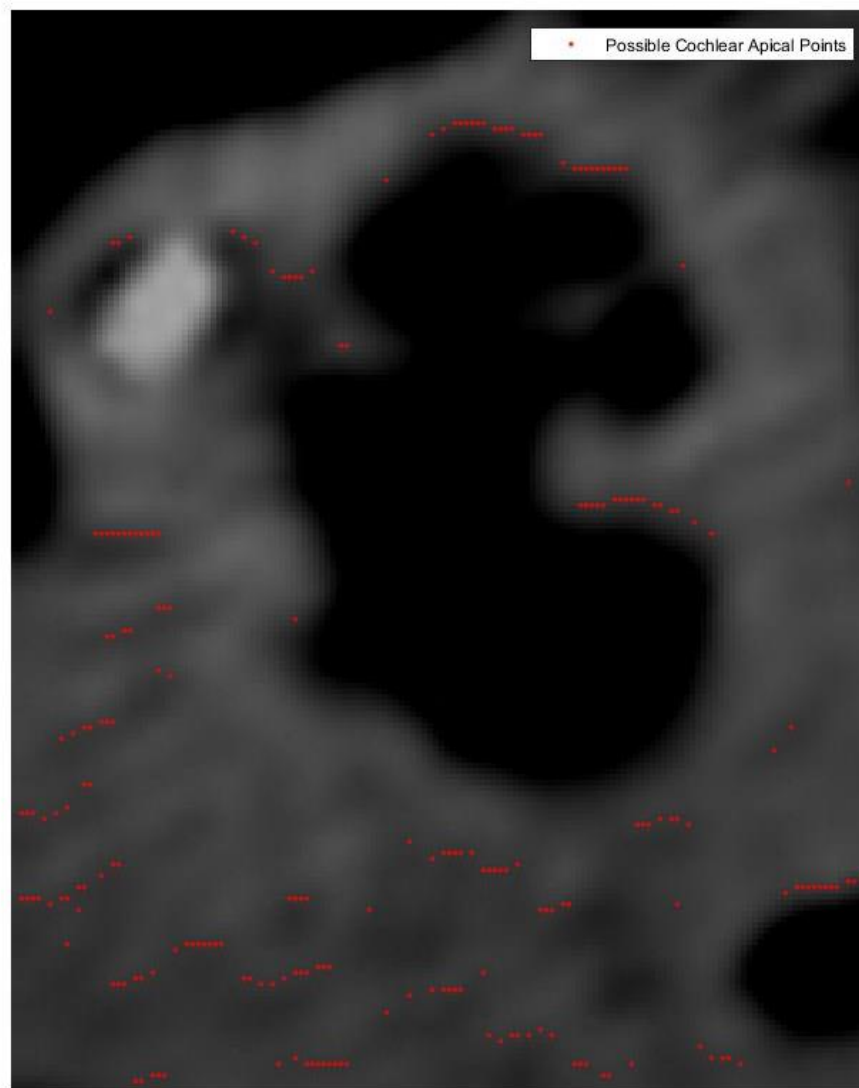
Example of the possible cochlear apical points found on the CT scan.
